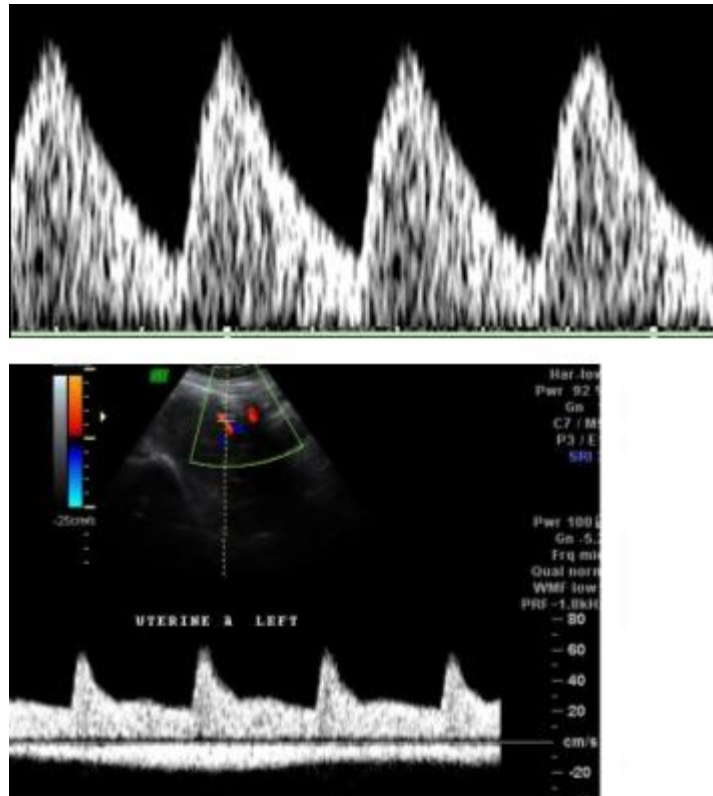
NORMAL UTERINE DOPPLER
